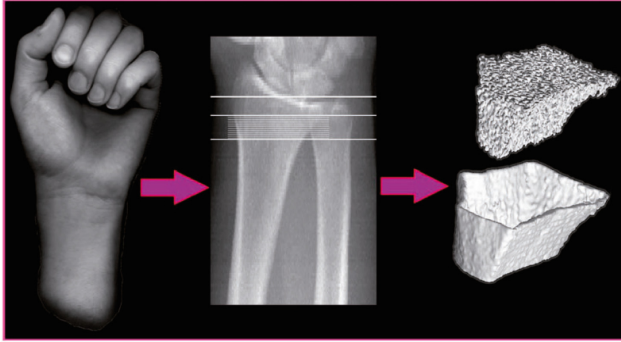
3D Medical Imaging of the distal radius using the μ CT system, with images showing the region of the distal radius imaged (center) and the resulting 3D trabecular and cortical envelopes (right) [21].
